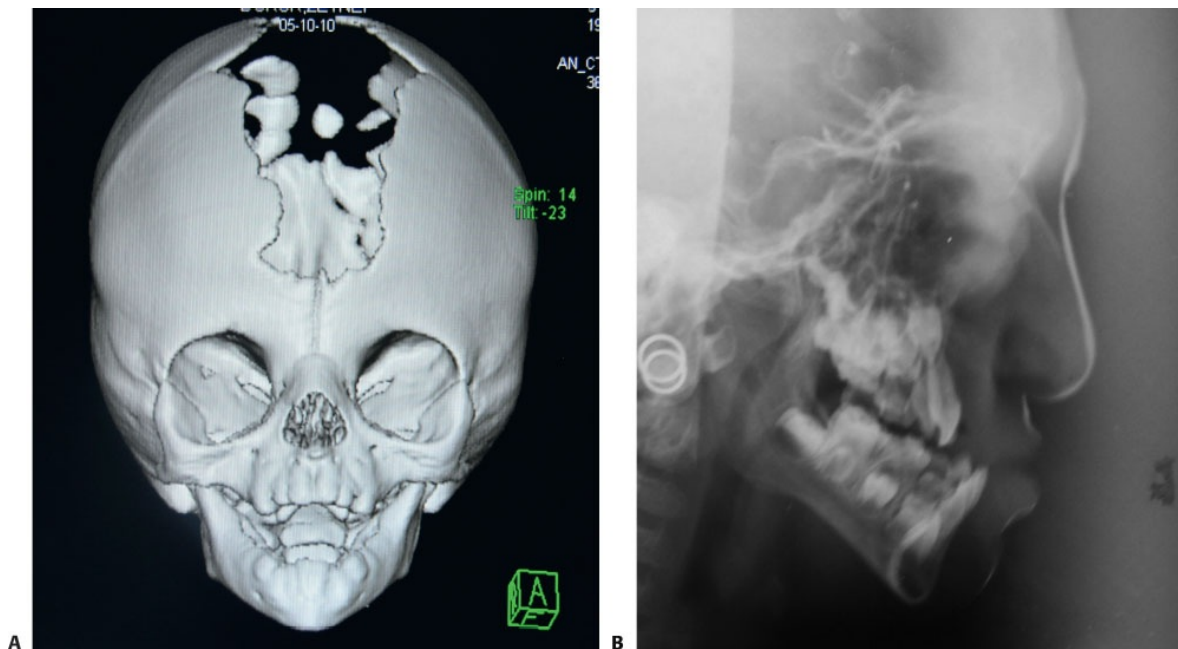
• A. 3D CT view of a patient with Apert syndrome. Bilateral coronal suture synostosis (note the ridging of the coronal sutures) and a large anterior fontanelle are
